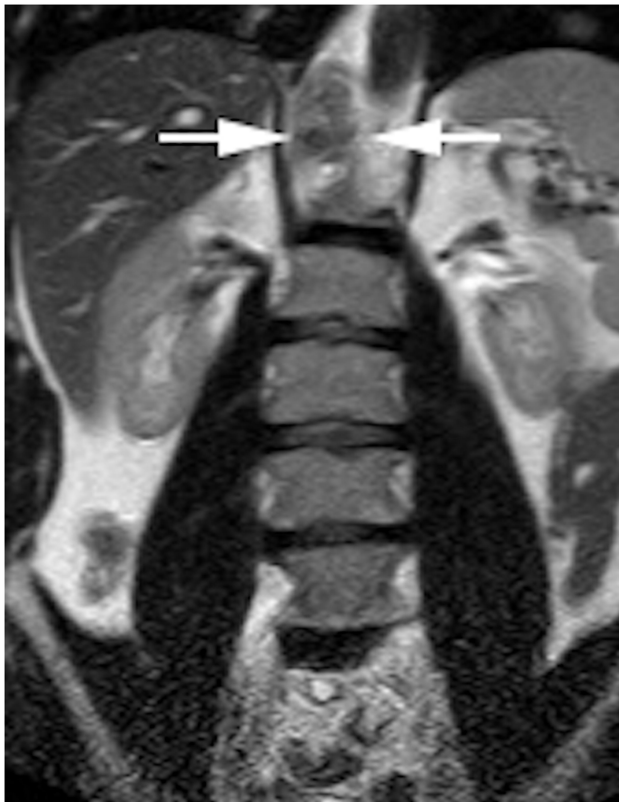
Use of MRI for retroperitoneal spread. Retrocrural heterogeneous T_2 intermediate signal intensity LN on right side.
